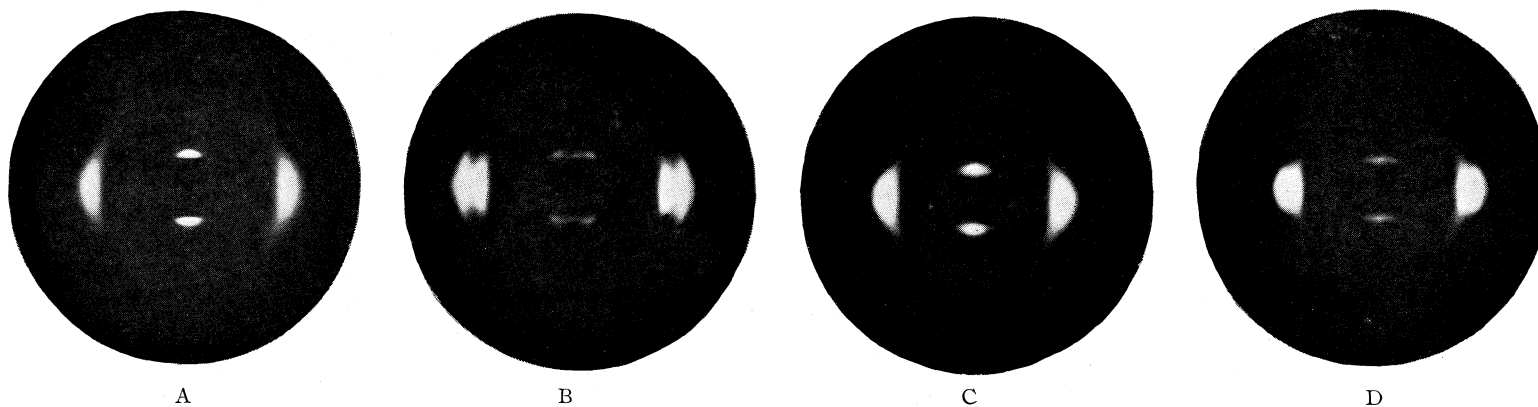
Effect of heat treatment on X-ray fiber patterns of typical polyamide and copolyamide: A, 100% 10-10, quenched; B, 100% 10-10 annealed; C, 80% 10-10 and 20% 6-6 quenched; D, 80% 10-10 and 20% 6-6, annealed.
